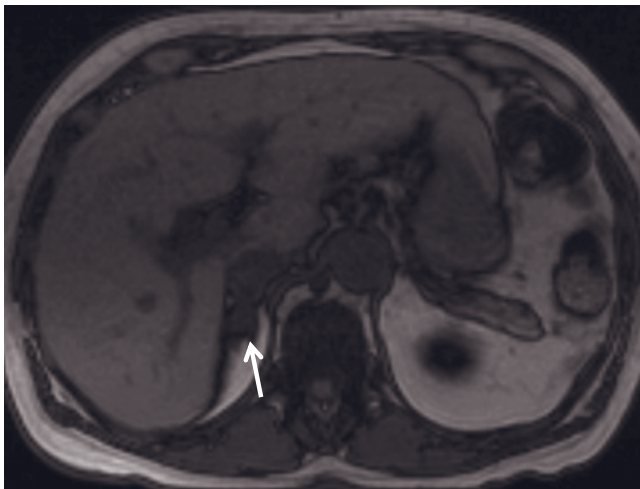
Adrenal adenoma—mild capillary blush. T1-weighted GE (*a*), T1-weighted out-of-phase GE (*b*), and immediate postgadolinium GE (*c*) images. Right adrenal adenoma demonstrates signal drop on out-of-phase image and mild capillary blush on immediate postgadolinium image. Note normal left adrenal (arrow, *a*). T1-weighted in-phase (*d*) and out-of-phase (*e*) SGE, T1-weighted postgadolinium arterial phase (*f*) and hepatic venous phase (*g*) fat-suppressed 3D-GE images at 3.0T demonstrate left adrenal adenoma in another patient. The adenoma shows signal drop on out-of-phase image (*e*) compared to in-phase image (*d*). Mild capillary blush is detected on the arterial phase image (*f*). Right adrenal adenoma 1.5 T vs. 3.0T. T1-weighted in-phase (*b*)
